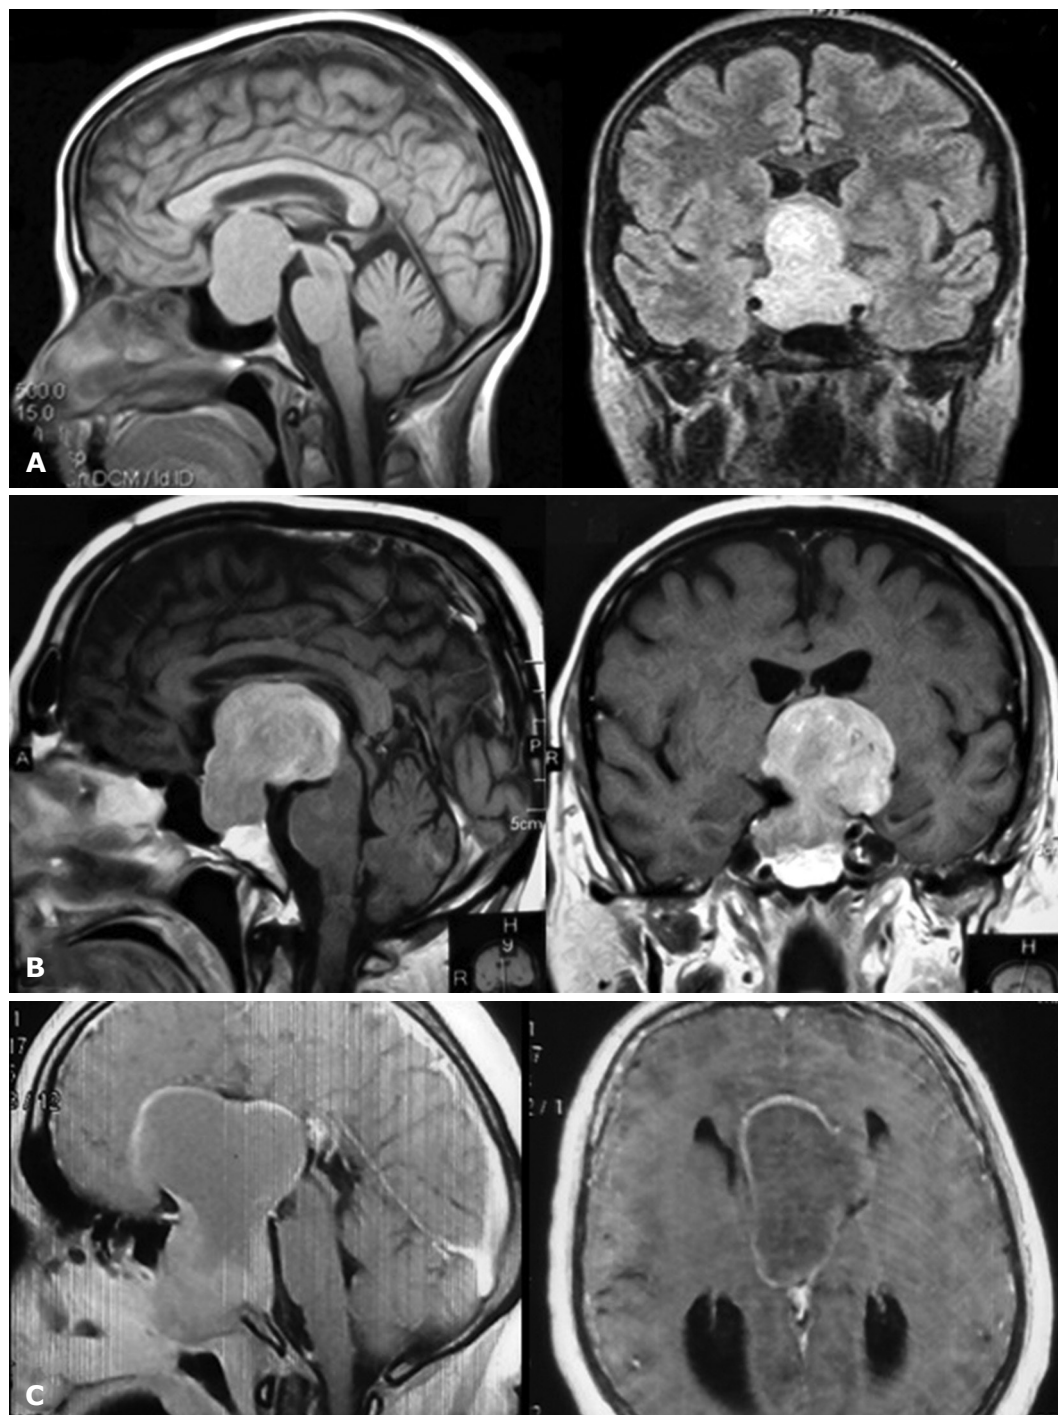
MR imaging (T1) of the types of extension of giant pituitary adenoma into the ventricular system: A – type 1; B – type 2; C – type 3
